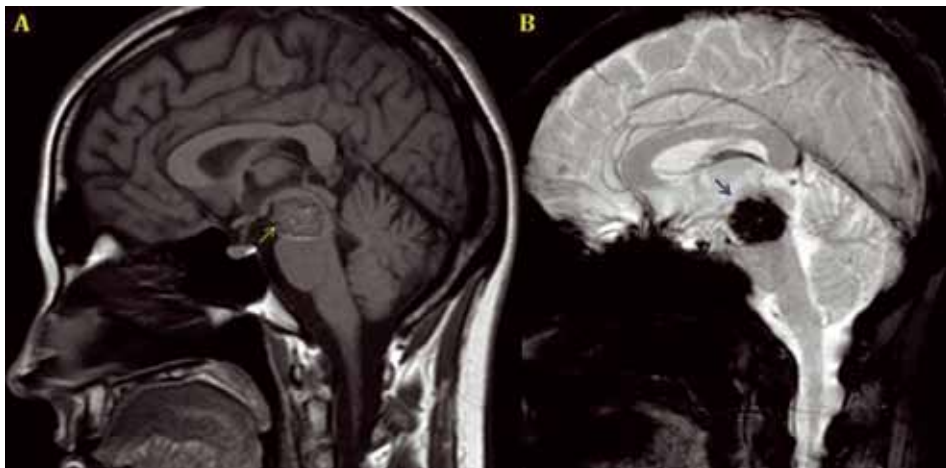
Sagittal MRI showing a right mesencephalic cavernoma (arrows) (A: T1-Weighted with Gadolinium contrast; B: EPI-Weighted).
